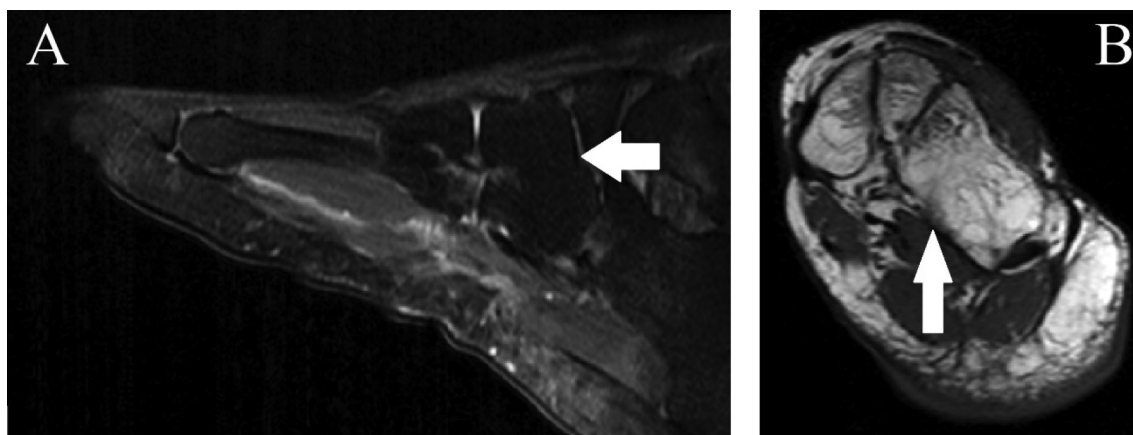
In A, MRI in the sagittal section with T2 FAT SAT sequence, and the coronal section with T1-weighted-image in B showing the lateral-cuboid cuneiform bone coalition (white arrow).
